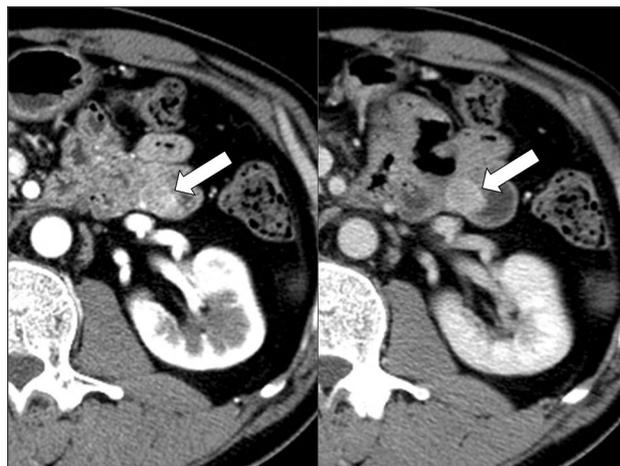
A 40-year-old man with an incidentally found, small bowel mass on CT. Multiphasic enhanced CT images show a small, well-enhanced, ovoid mass in the jejunum on arterial (left) and portal phase (right) images (arrows). This mass was confirmed as very low-risk GIST
